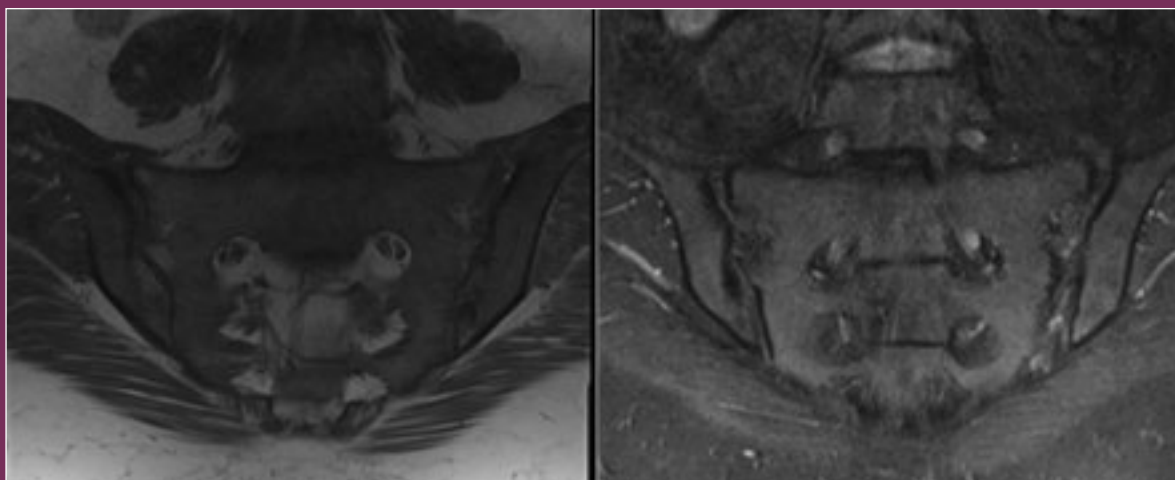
MRI Pelvis in coronal oblique views demonstrating sacroiliitis in T1 (left) and STIR (right).
